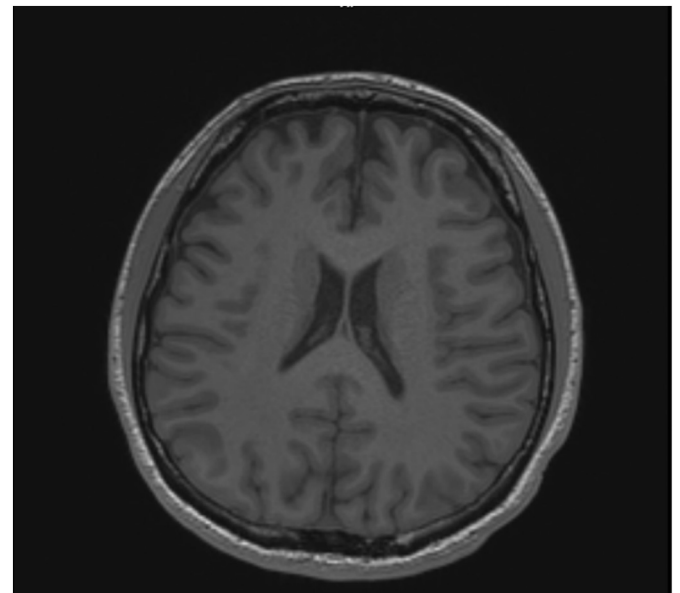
MRI brain w/o contrast, axial view. No abnormal cortical signal. No hydrocephalus, mass effect, midline shift or abnormal extra-axial fluid.
